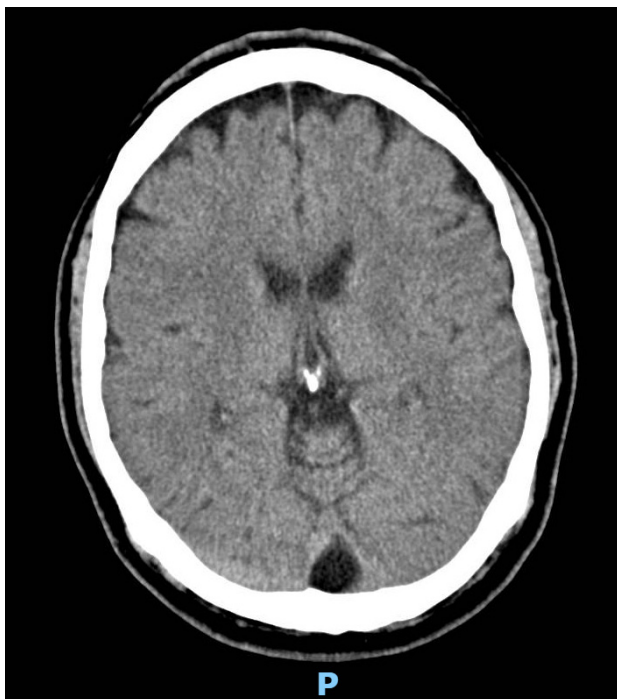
An axial CT scan of the brain shows a MCM confined between two falx cerebelli.
